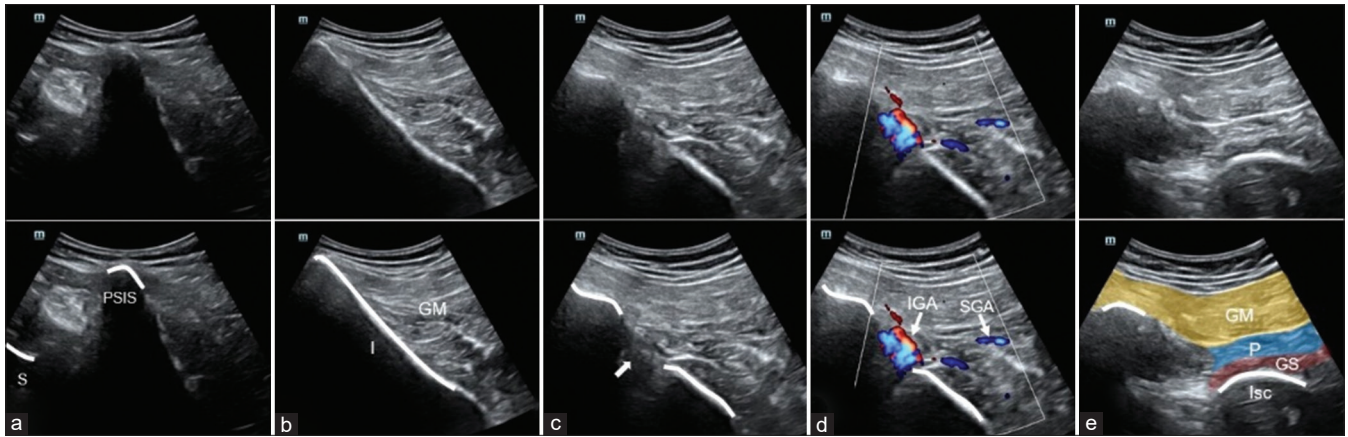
Ultrasound-guided piriformis injection: (a) Axial image showing the posterior superior iliac spine, (b) axial image showing the iliac bone (curved line) and gluteus Maximus, (c) axial image showing the sciatic notch (arrow), (d) axial image showing the vascular structures, (e) longitudinal image showing the piriformis muscle. PSIS: Posterior superior iliac spine, S: Sacrum, I: Iliac cortex, GM: Gluteus Maximus muscle, IGA: Inferior gluteal artery, SGA: Superior gluteal artery, P: Piriformis muscle, GS: Gemellus superior muscle, Isc: Isciun
